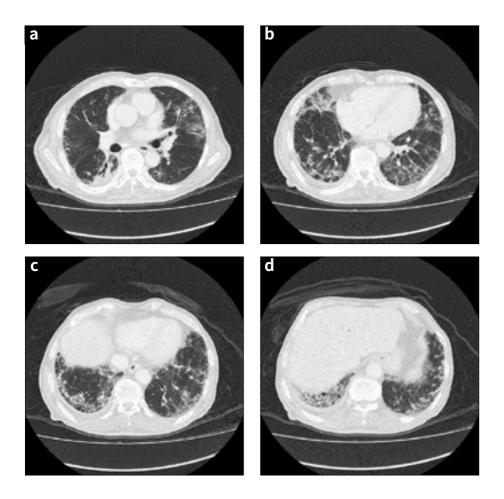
High-Resolution Computed Tomography
